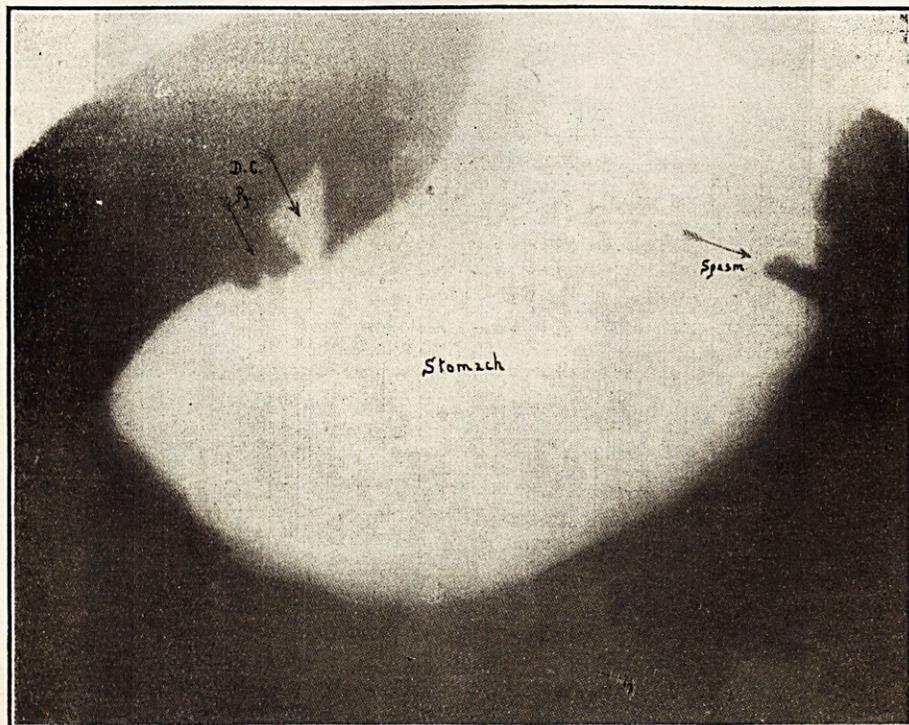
Examination 6 hours after the Bismuth meal. Radiograph shows (1) practically no Bismuth had passed out of the stomach (2) a spasm on the greater curvature (which was present at the first three examinations) (3) an irregular Duodenal Cap and Pylorus.
